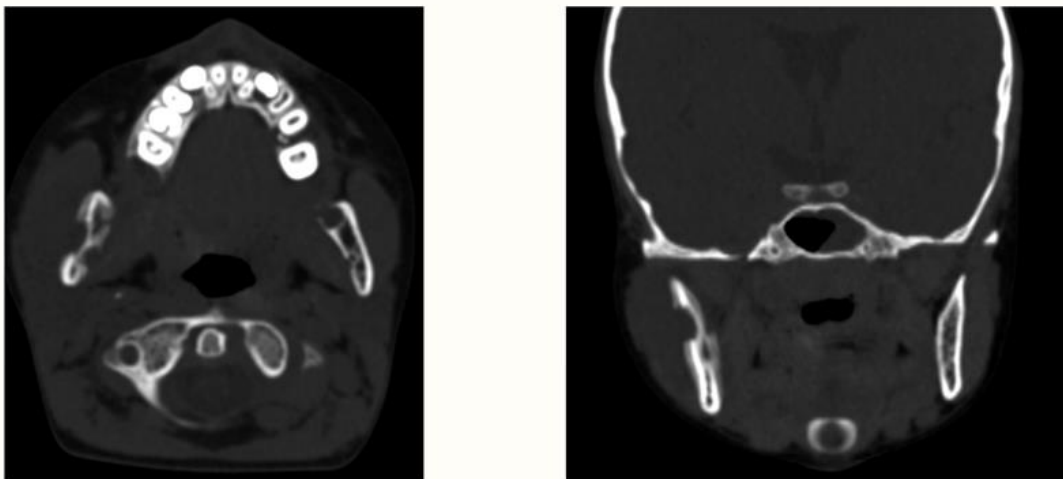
CT scan of 10 year old male child
